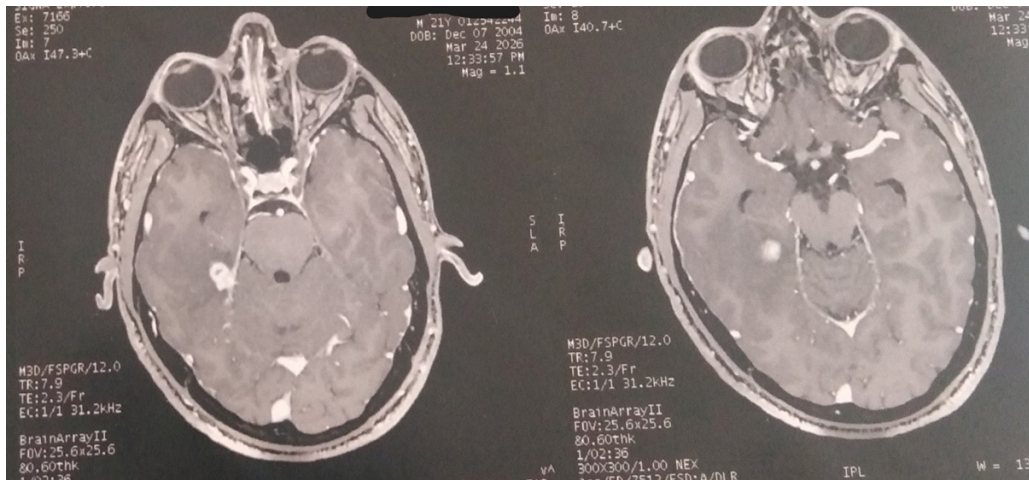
Brain MRI showing a well-defined nodular lesion in the temporal region.
